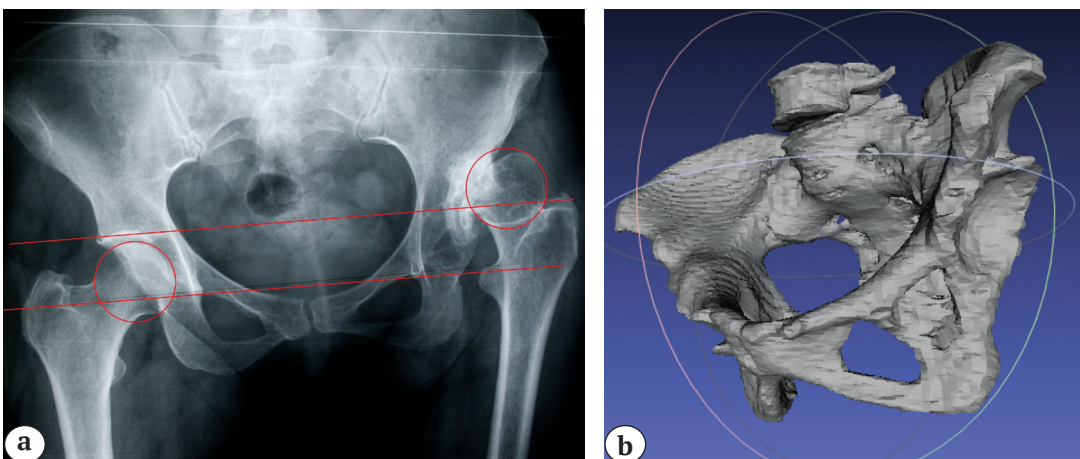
Overall pelvis X-ray – femoral head is displaced cranially approximately at 75% of its height (a), correspondingly, it's Crowe III type, however, 3D reconstruction of CT views demonstrates complete dislocation of the femoral head (Crowe IV or C2 type by Hartofilakidis) – true and false cavities have no common space (b)
